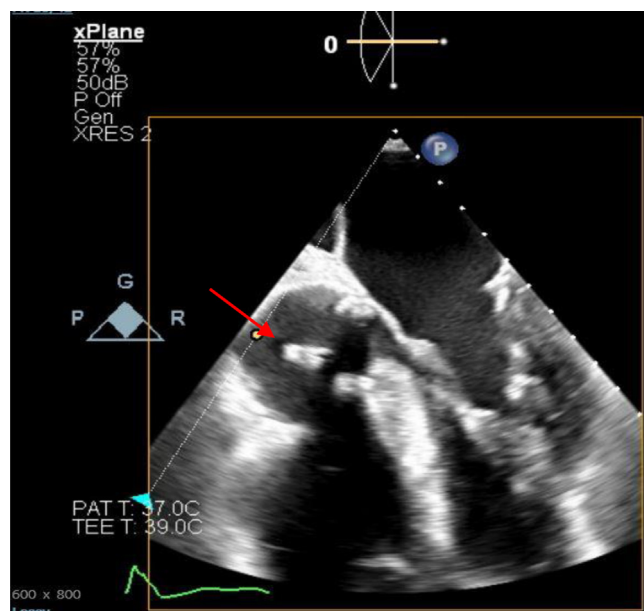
Transthoracic echocardiography showing ascending aortic graft vegetation (arrow).
